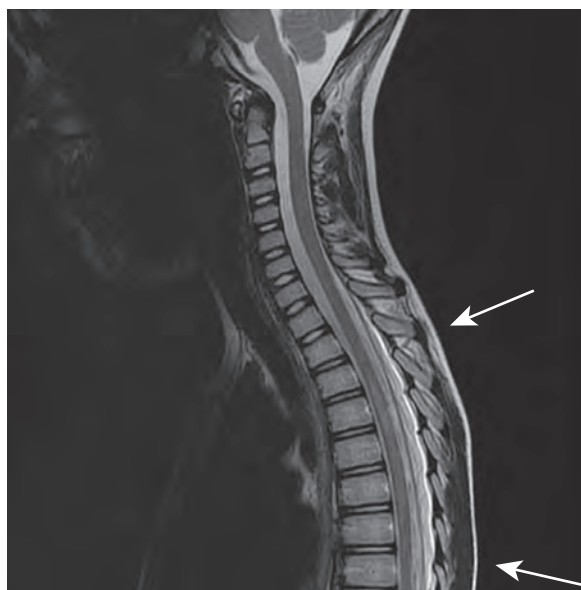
Sagittal T2-weighted magnetic resonance image of the spine of an 8-year-old boy with lower extremity weakness and urinary retention. Increased signal intensity of the spinal cord is noted from T3 to T8 (arrows).
